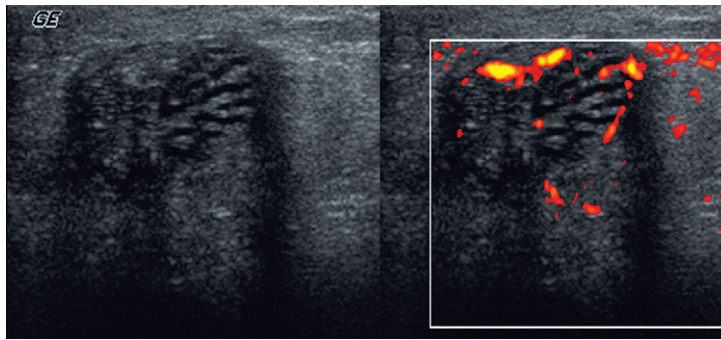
Grey-scale and power Doppler image focused on the region of the mediastinum testis. A collection of small tubules is present. Power Doppler shows the absence of flow within these tubules, consistent with dilated rete testis.
